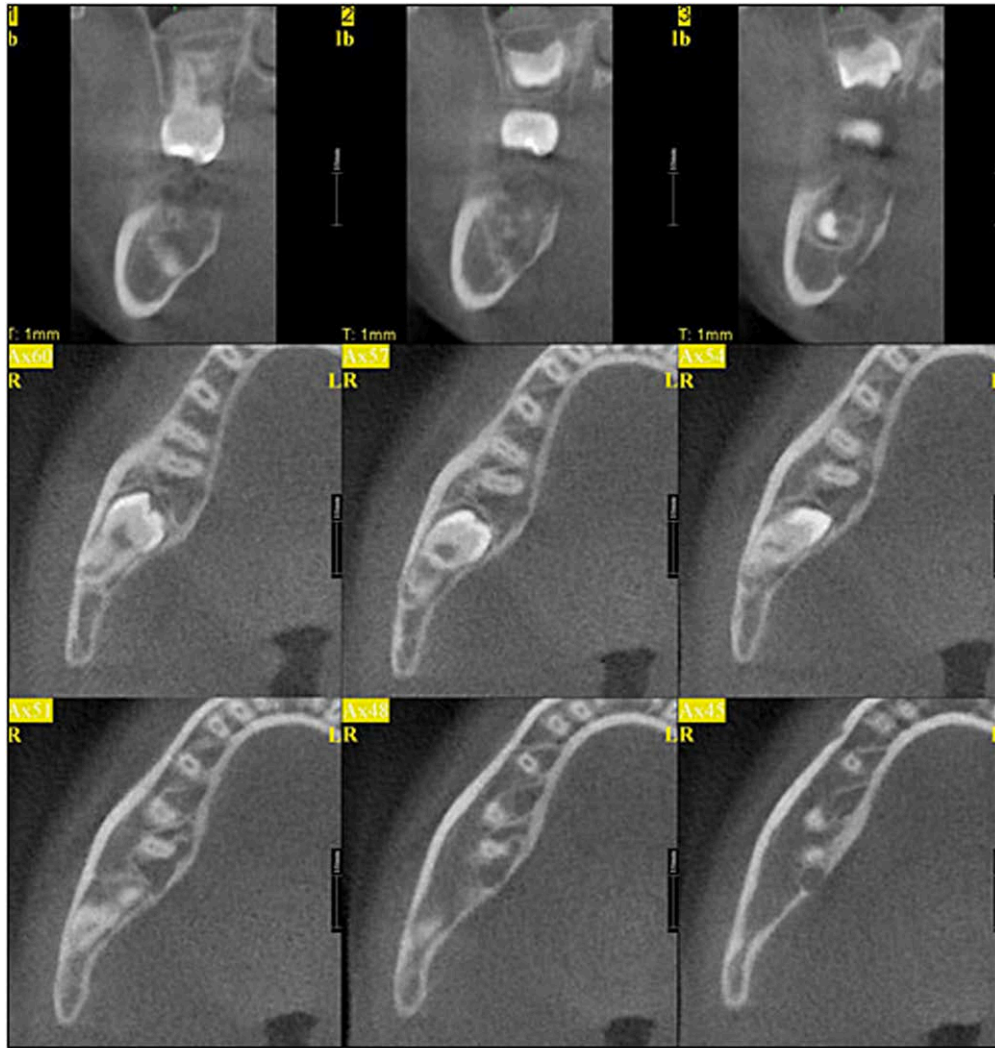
Cone beam CT showing expansion adjacent to impacted tooth #31.
